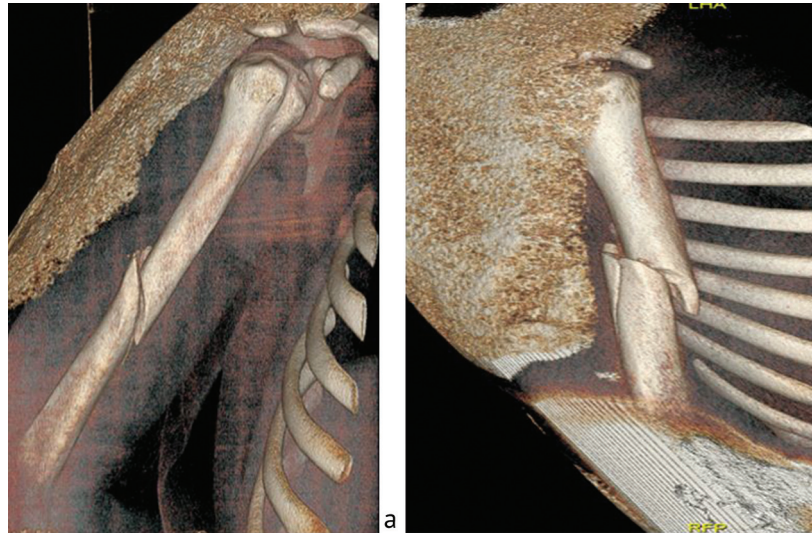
3D reconstructions of CT scans of the right humerus of patient K. showing (a) AP view, (b) oblique view
